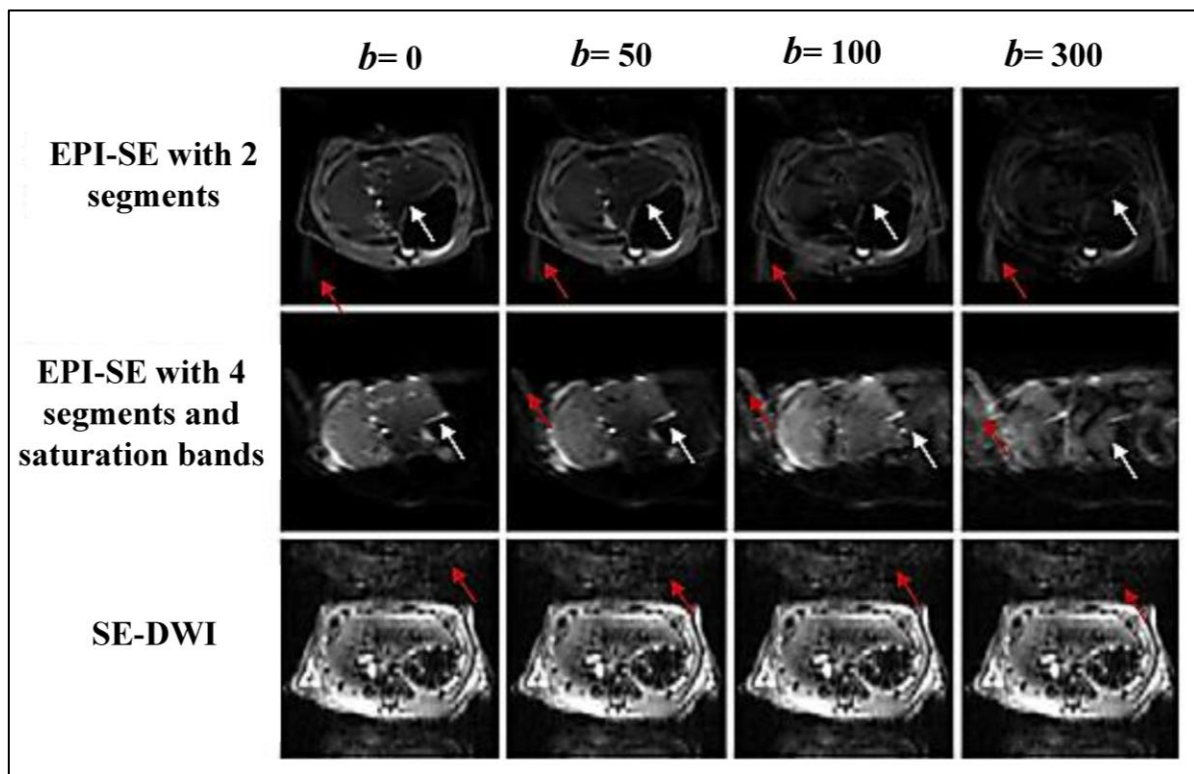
An *in vivo* DW images acquired with EPI-SE and SE-DWI sequences (with  $b$ -value = 0, 50, 100, and 300  $s/mm^2$ ) showing the effect of motion artefacts on images (red arrows). Motion artefact are more evident when the phase encoding direction is oriented left to right (middle images) compared to anterior to posterior direction (top images). Note that the motion artefact gets worse with higher  $b$  values in EPI-SE sequences. Marked distortion artefact on EPI images at liver-stomach margin are detectable in EPI-SE sequence (white arrows).
